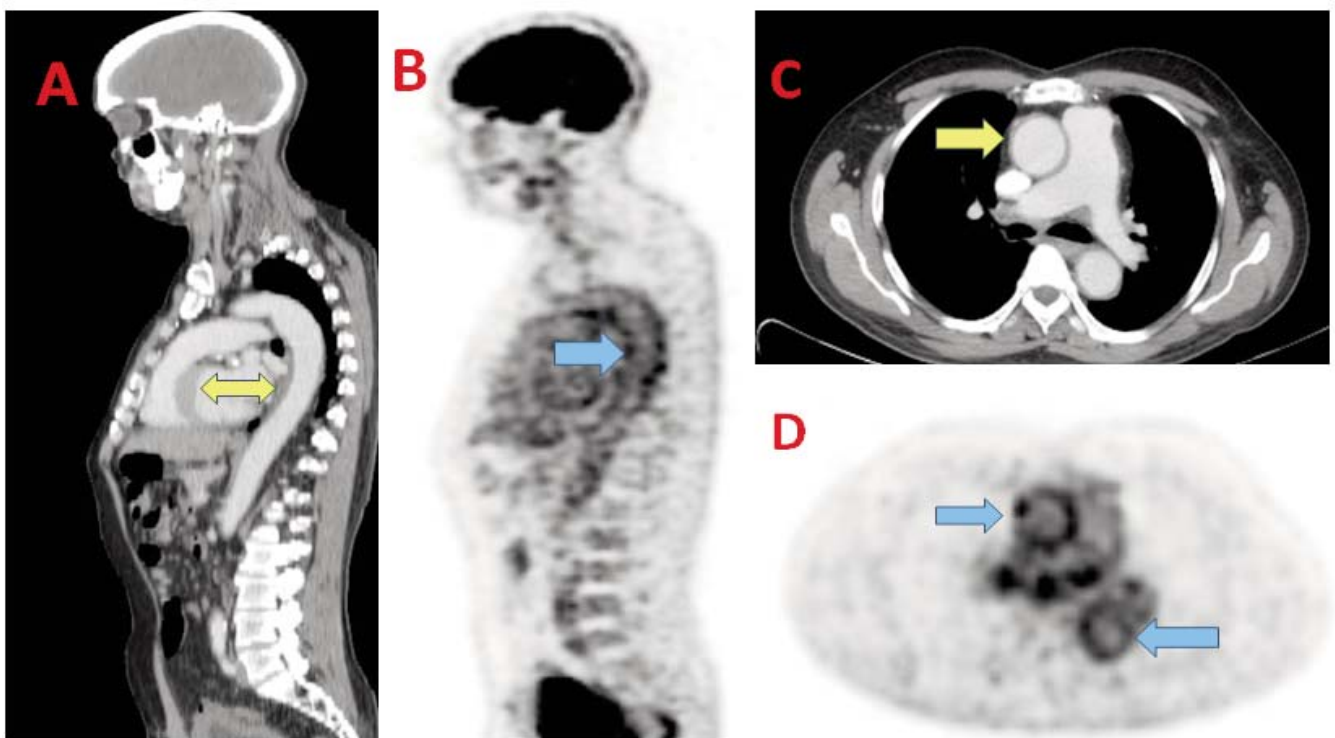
Image A and B are sagittal images of CT and PET component respectively and C and D are respective transverse images. Yellow arrows point to major vessel wall thickening and absence of calcification and blue arrows mark to corresponding FDG uptake on PET indicating vasculitis.
